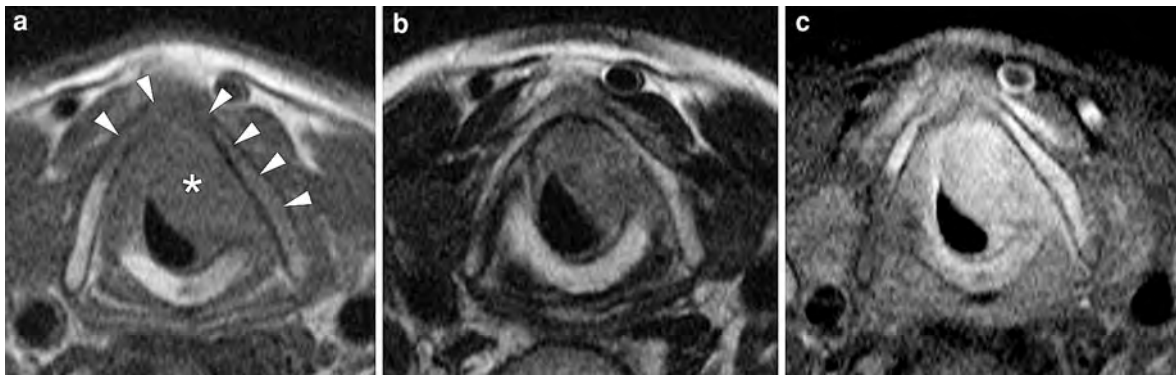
Axial MR-images in a patient suffering from transglottic cancer. A large soft tissue mass is seen, centered on the left glottis/subglottis, extending over the midline. On the T1-weighted spin echo image (a), signal loss is seen in the adjacent part of the thyroid cartilage (*arrowheads*). On the T2-weighted image, the tumor shows a lower signal intensity than
